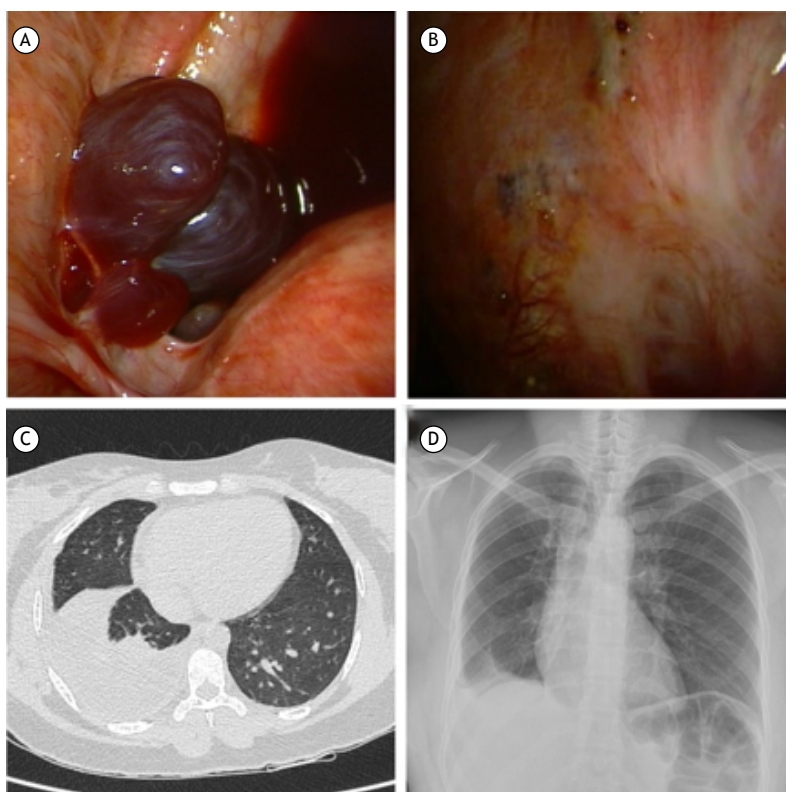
A) Wine-red nodules on the diaphragm visualized during medical thoracoscopy; B) Small punctiform wine-red lesions on the parietal pleura; C) Chest CT at admission, showing right-sided basal pleural effusion; D) Chest X-ray 1 month after the initiation of gonadotropin-releasing hormone therapy.
